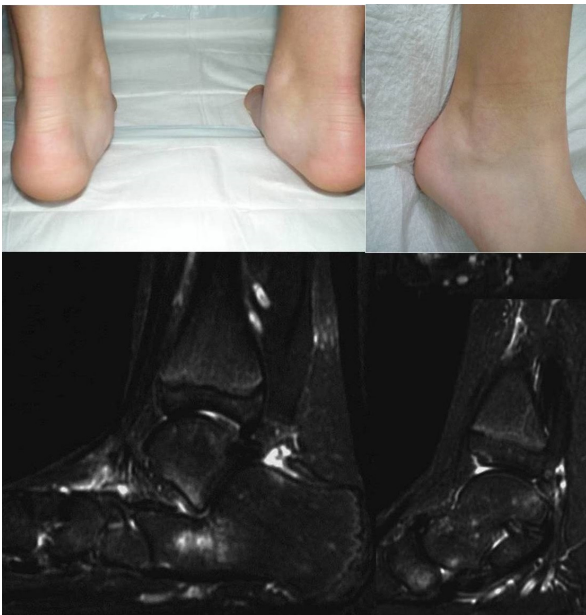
An 11-year-old girl had a two-year history of painful, rigid flat feet and peroneal spasm. T1-weighted MRI with fat saturation and contrast showed tenosynovitis, effusion, and synovial enhancement in the ankle, subtalar, and Chopart joints, and subarticular bone marrow edema.
